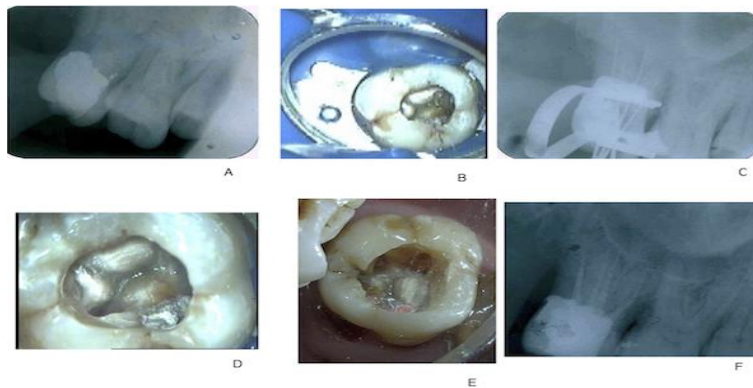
Fig A Preoperative radiograph showing already accessed and temporarily filled 17
